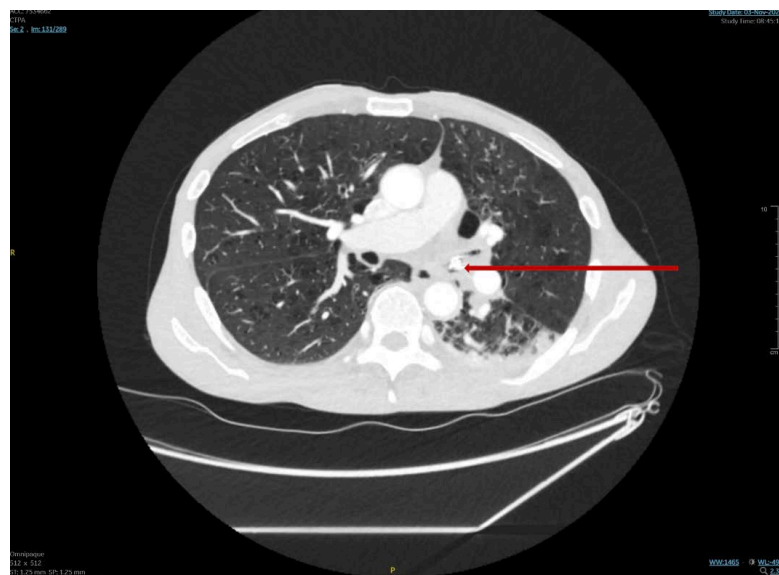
CT-PA showing foreign body in the left main bronchus.
